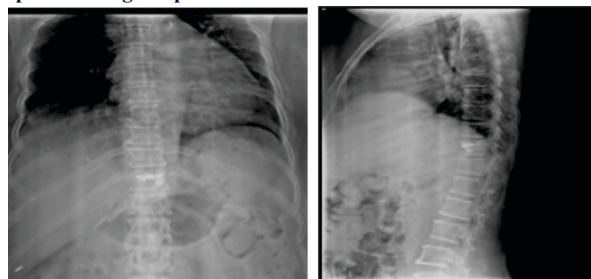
shows AP and lateral view of spine of immediate post op x-ray treated with vertebroplasty.
